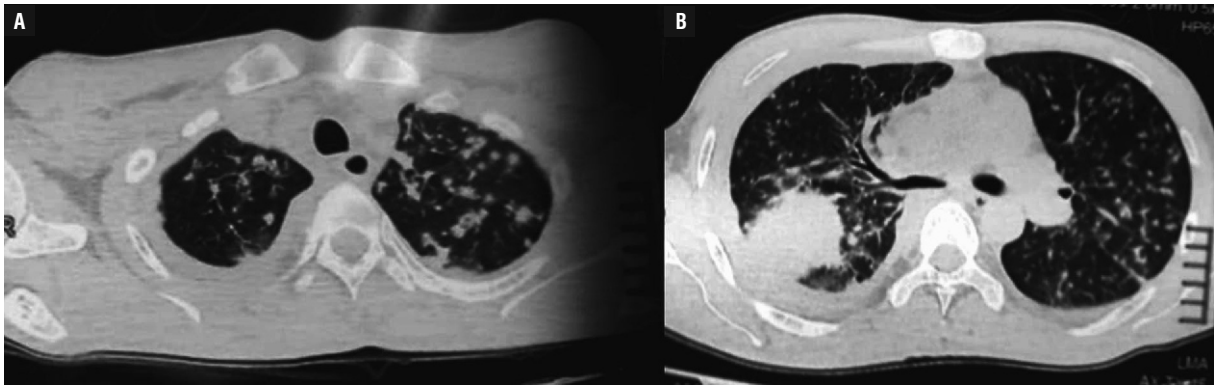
A. Chest computed tomography showing multiple bilateral diffuse pulmonary nodules; B. Lung mass with irregular borders in S6 and adjacent pleural effusion, in addition to the presence of nodules
